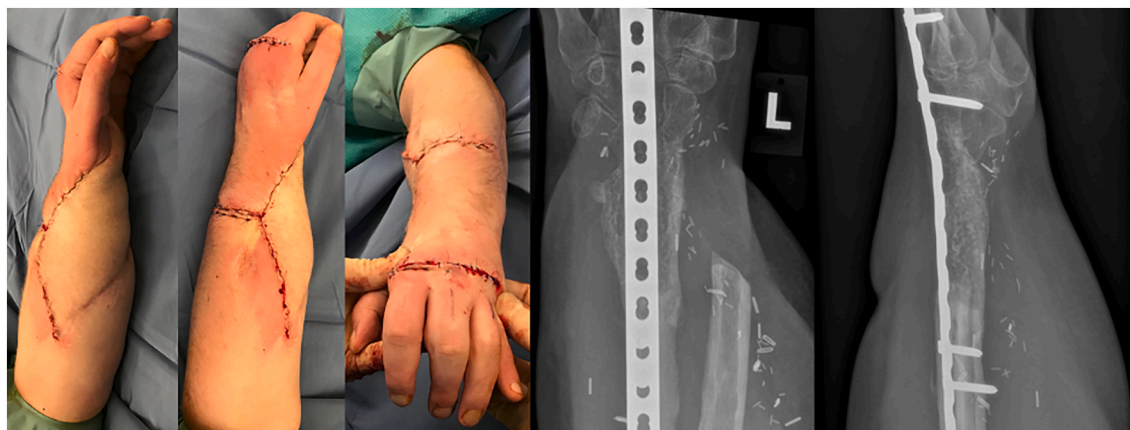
Clinical photographs post debulking, and x-rays demonstrating union.
